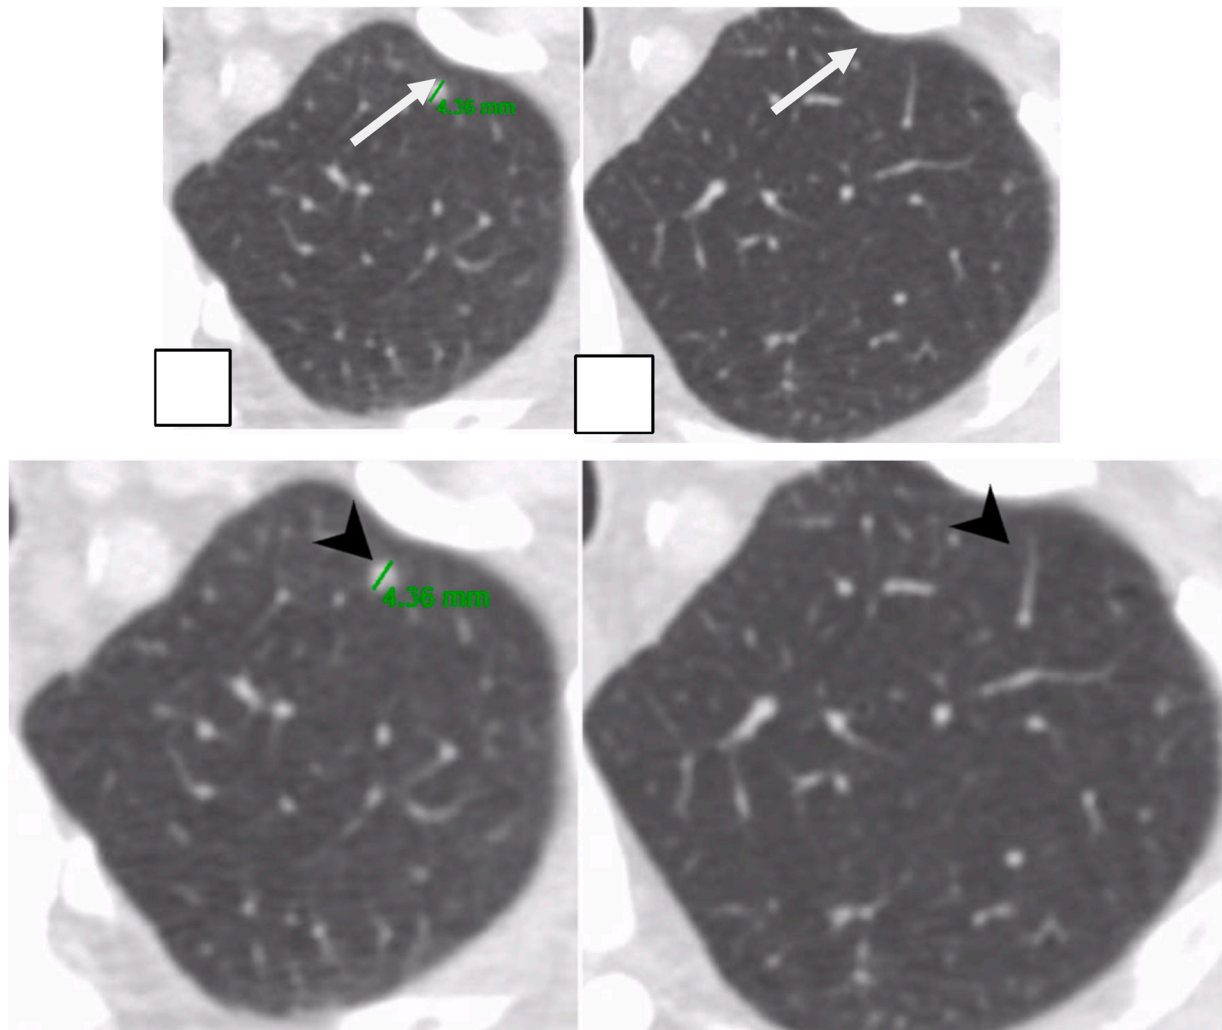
Non-enhanced chest CT, axial view, lung window, of left upper lobe in a 72-year-old patient diagnosed with pancreatic adenocarcinoma. Over a 6-month period during which the patient underwent chemotherapy, a PN (arrows) detected in a monitoring scan was found to have reduced in size from 4.4 mm (A) to a punctate, non-measurable nodule (B).
